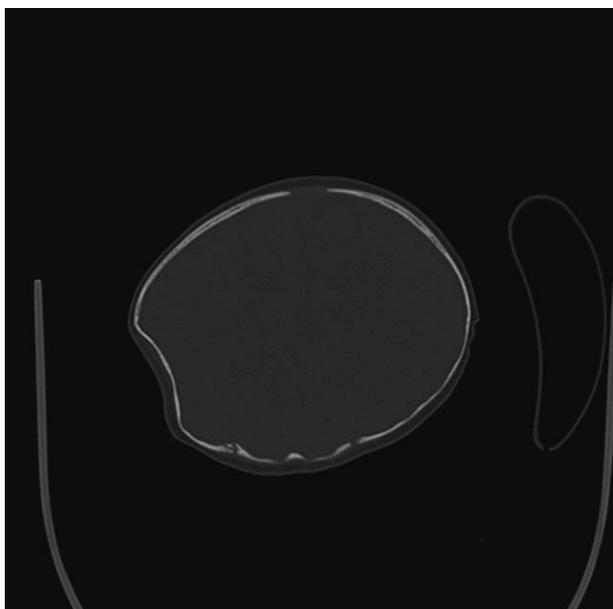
Axial computed tomography scan, demonstrating a depressed parietal skull fracture.
